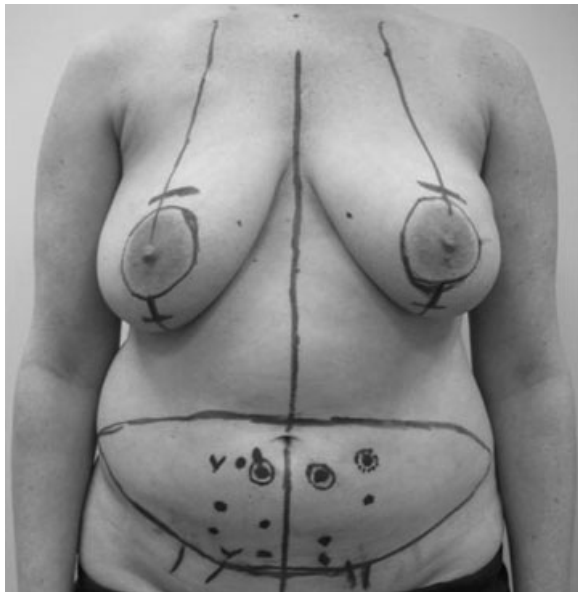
Photograph demonstrating preoperative markings. Dot surrounded by circle represents optimal perforator detected by magnetic resonance imaging angiography (MRA), Dot surrounded by broken circle represents a second-choice perforator detected by MRA. Dot represents arterial signal detected by Doppler ultrasound. V represents venous signal detected by Doppler ultrasound.
